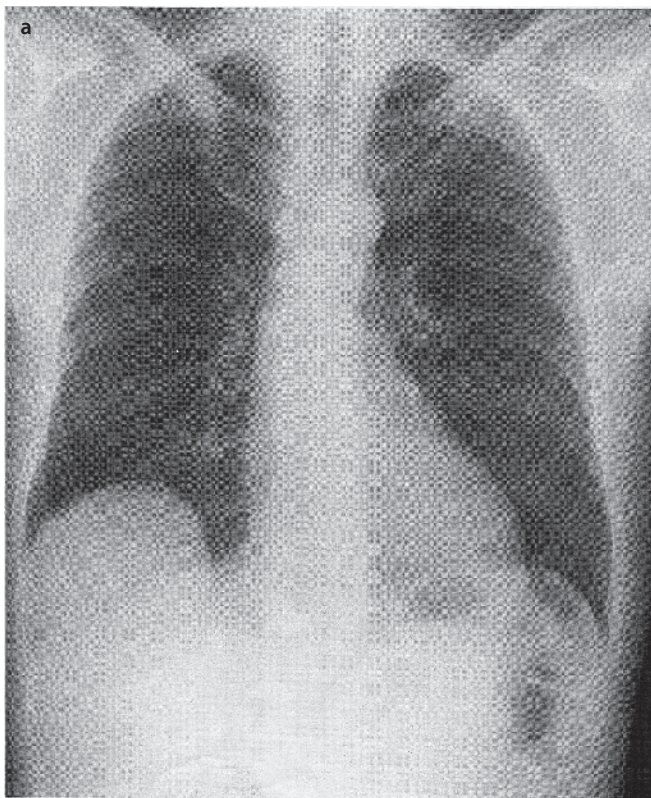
Rare finding of a lipoma in the diaphragm. Smoothly demarcated tumor (*arrow*) presenting in similar fashion in CT showing fat density
